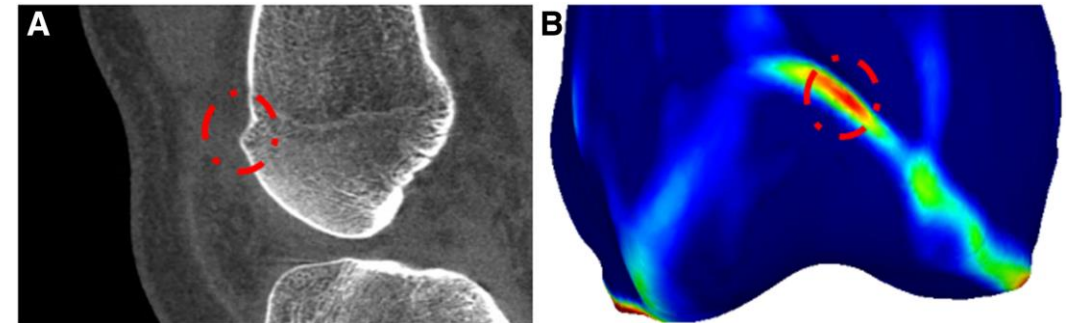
Raters found that curvature analysis(B) helps to better determine ridges compared to looking at high resolution CT-scans (A).
